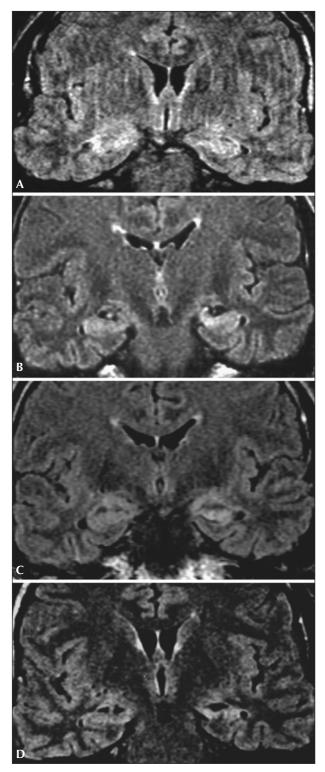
Coronal MRI sections showing the initial high signal intensity in bilateral hippocampal formations, left more than right, and the evolution over time. A) FLAIR MRI at the time of the acute phase. B) Fast spin echo inversion recovery (FSEIR) at admission. C) FLAIR MRI at the time of relapse.
